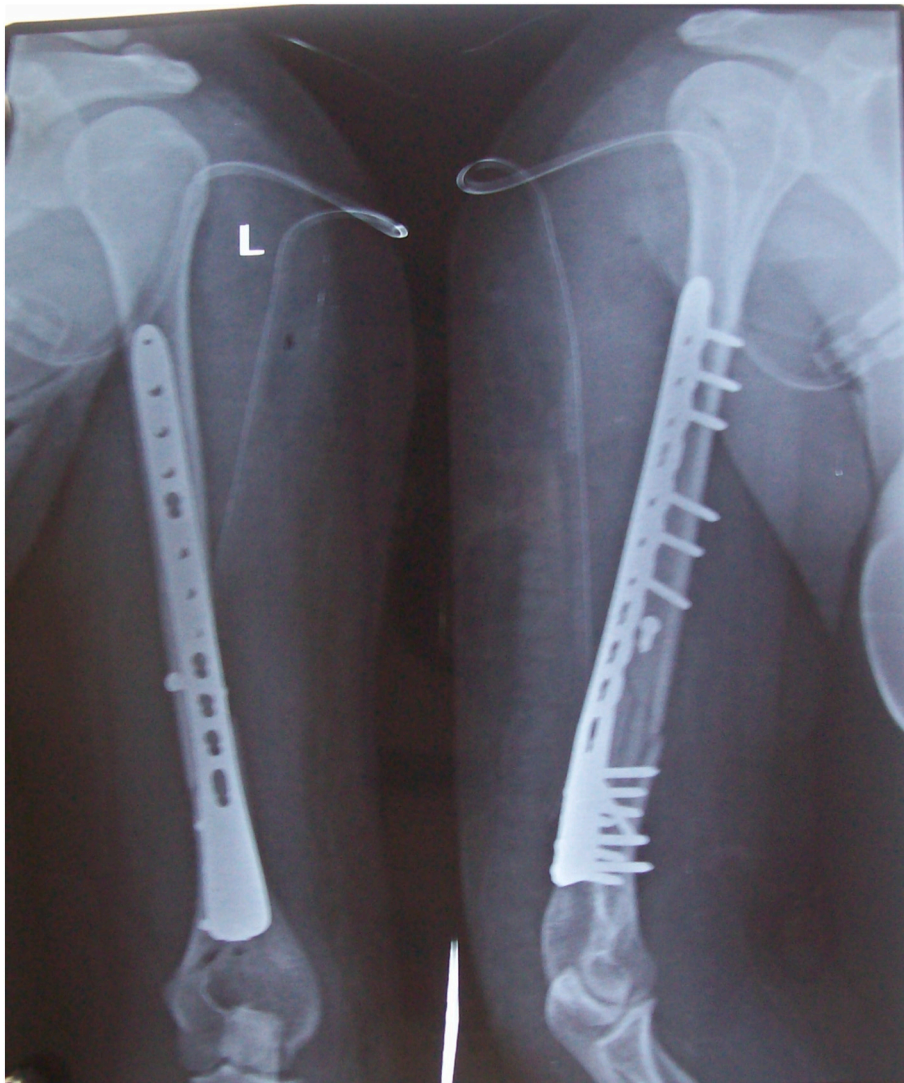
Immediate postoperative radiographs after open reduction and internal fixation with a 3.5 mm DMTP locking plate showing satisfactory alignment.
